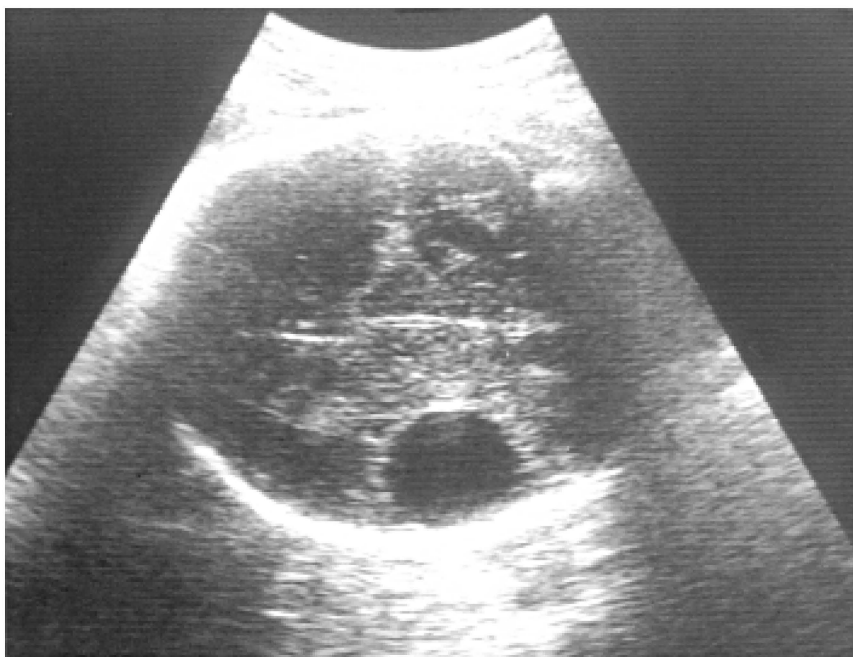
Prenatal ultrasound during the third trimester performed at the level of third ventricle depicts a homogeneous anechoic extraaxial lesion at the right Sylvian fissure with slight compression on the right operculum.
